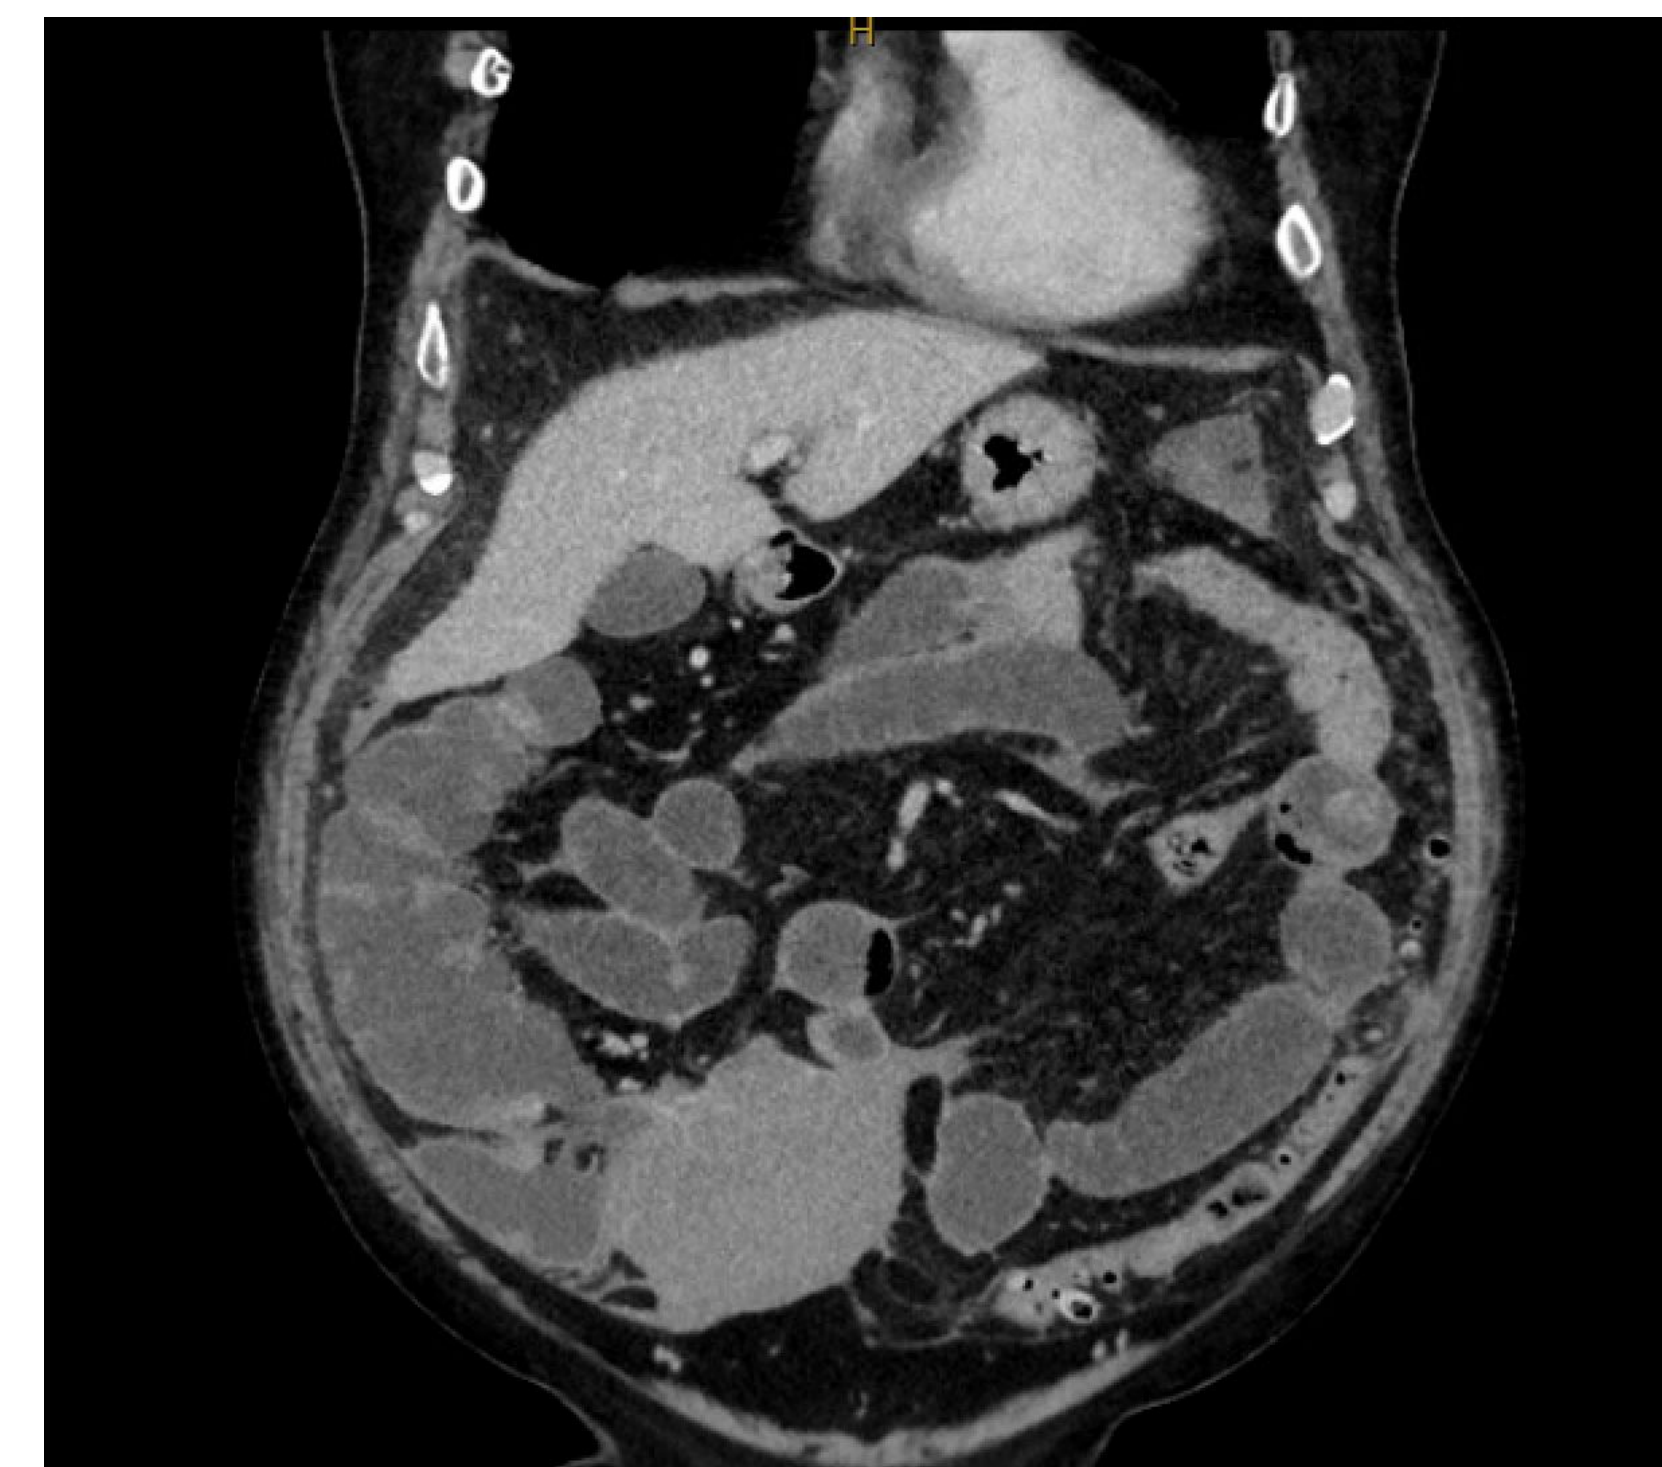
Patient's CT abdomen/pelvis on presentation.
